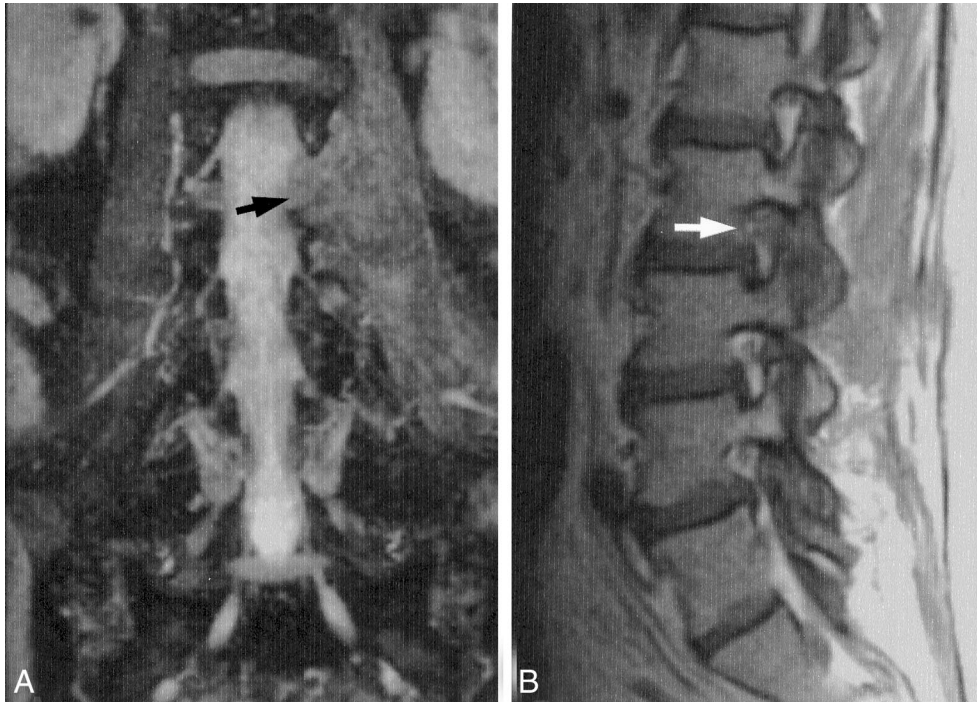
Magnetic resonance images (MRI) 2 months after epidural anesthesia. (A) T2* weighted lumbar MRI in coronal section showed that the left iliopsoas muscle was still swollen. The abscess has spread through the L2-L3 foramen (arrow). (B) T1-weighted lumbar MRI in parasagittal section showed disappearance of fat at the left L2-L3 foramen (arrow).
